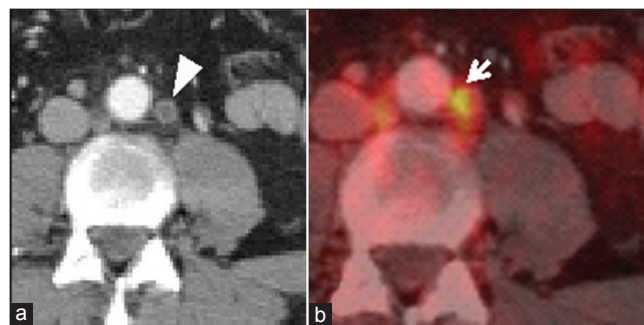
71-year-old male, initially diagnosed with metastatic urothelial cancer, presenting with biopsy proven recurrent disease. a) Contrast enhanced-computed tomography (CT) shows a round para-aortic node measuring 10 mm with central necrosis (arrowhead). b) Fused 18F-fluorodeoxyglucose (FDG) positron emission tomography/CT (right) shows FDG-avidity with SULmax 5.6 (white arrow).
